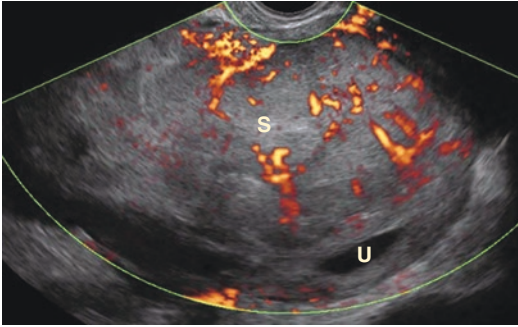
Power Doppler image of a sarcoma in the anterior wall of the uterus with irregular internal vascularization: U uterus; S sarcoma
